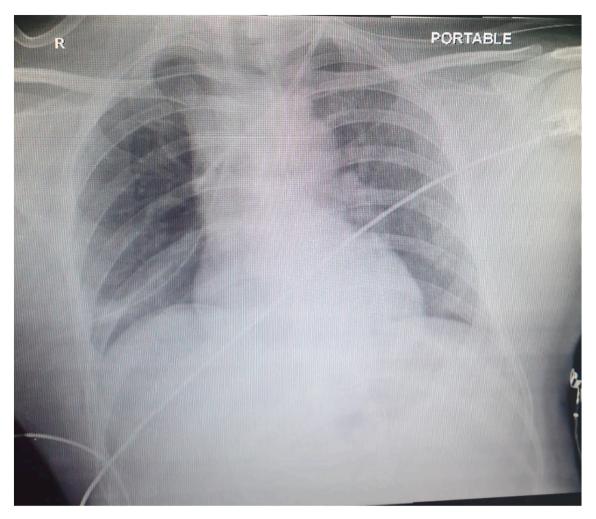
Post-operative Xray.
